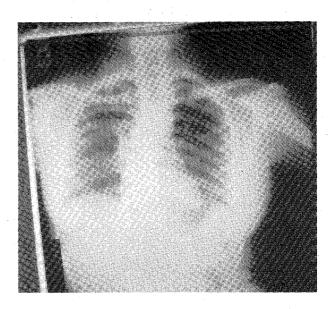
Chest X-ray showing bony fusion of posterior ribs of patient with Goldenhar syndrome
